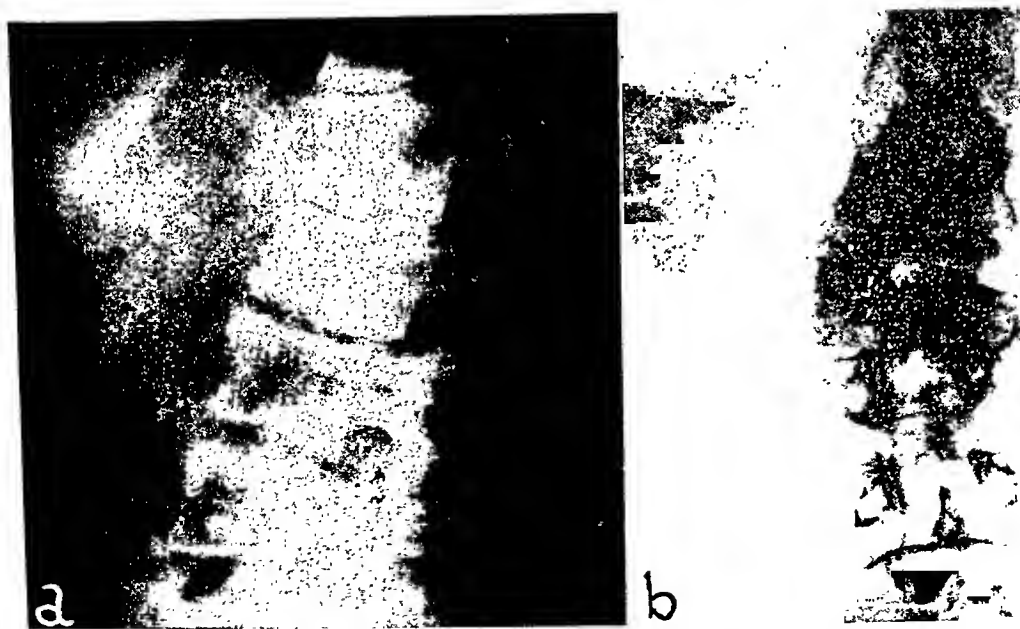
a*. Mr. R. H., aged forty-four. Lateral roentgenogram showing backward displacement of second lumbar vertebra on third lumbar vertebra with marked narrowing of the intervening space. Note reactive changes including subarticular sclerosis, lipping, spur formation, etc., and "hour-glass" appearance of the intervertebral foramina. Note characteristic "step-ladder" appearance of the other lumbar vertebrae due to rotation. *b*. Anteroposterior projection reveals rotary and lateral scoliosis of the lumbar spine which accounts for "step-ladder" effect noted in *a*.
